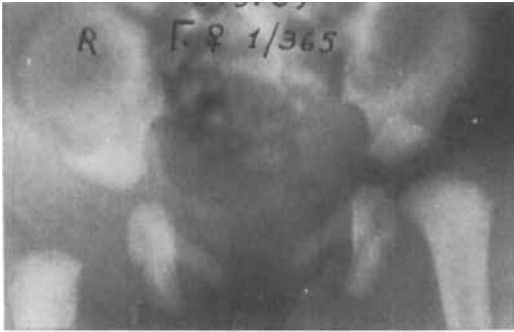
Anteroposterior and lateral X-rays of a 1-day-old girl showing upward and anterior displacement of the shaft of the left femur.
